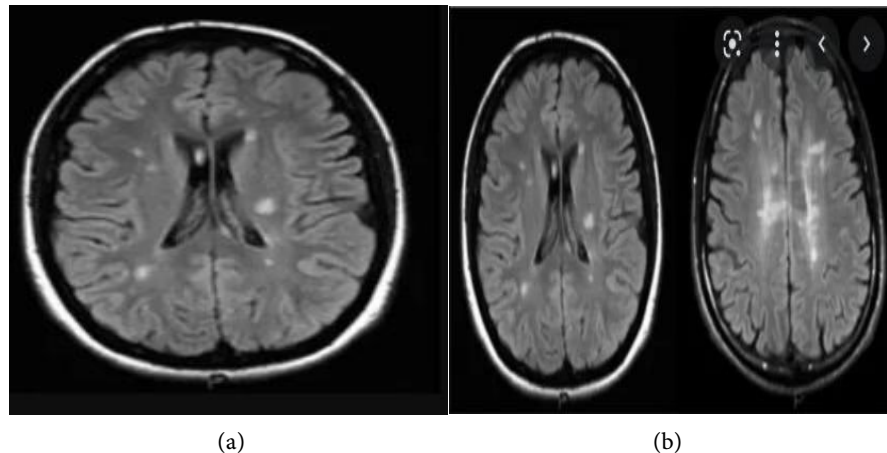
Temporal dissemination: MRI T1 sequence after injection of gado shows more than 6 rounded hyper signals; oval in the periventricular and juxta cortical less than 3 mm thick performed after an interval of 1 month meeting the criteria of Macdonald 2010.
